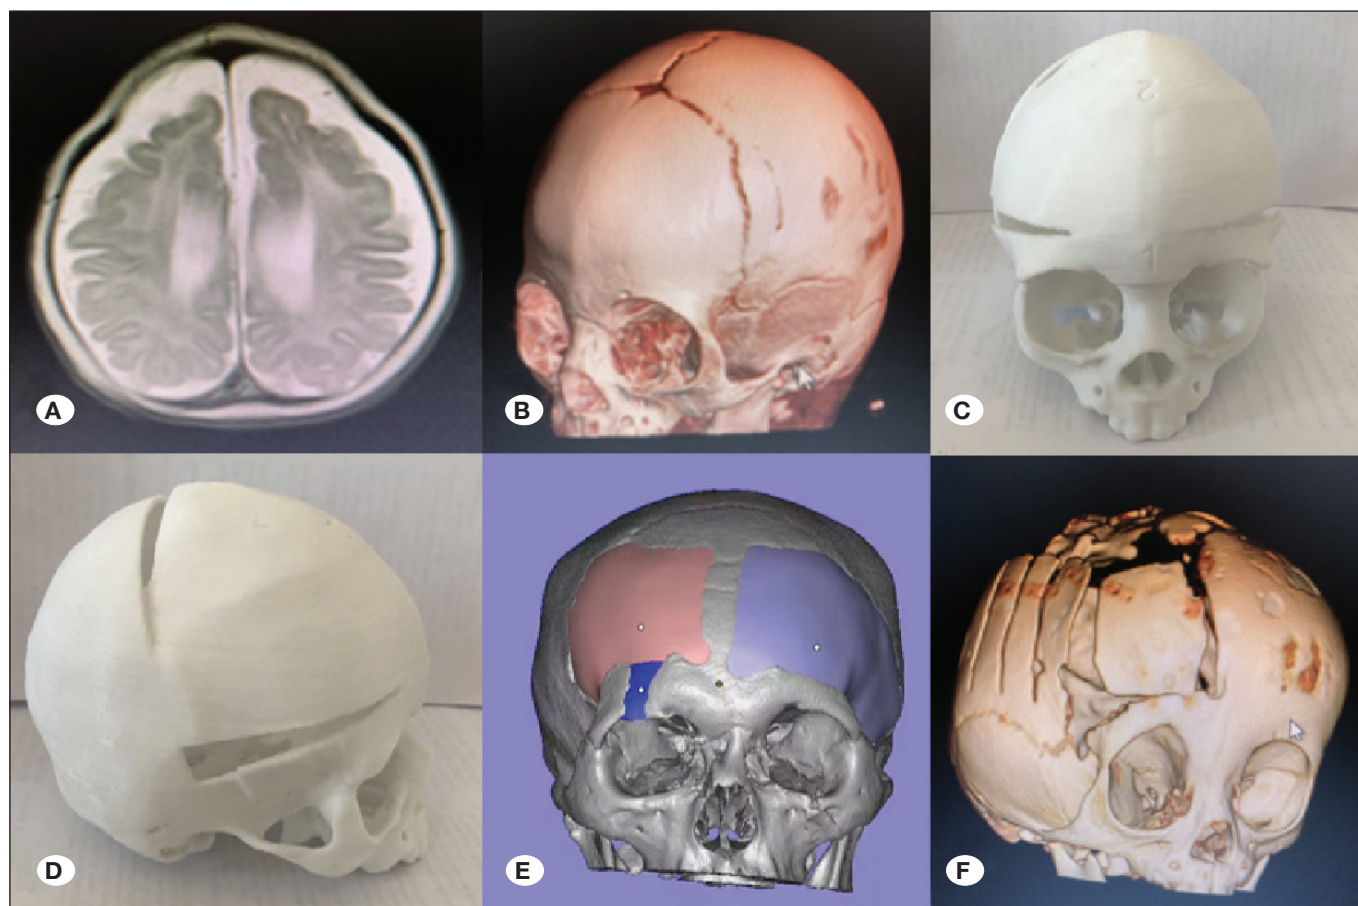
3D printing technique assisted surgical treatment of infantile cranial stenosis. A) Preoperative MRI image B) preoperative Head type; C, D) preoperative 3D printing model: assist the fronto-orbital band retraction technique and guide the formulation of the operation plan E) 3D printing model during operation to guide the operation of frontal bone reconstruction; F) The CT images reexamined after operation.
